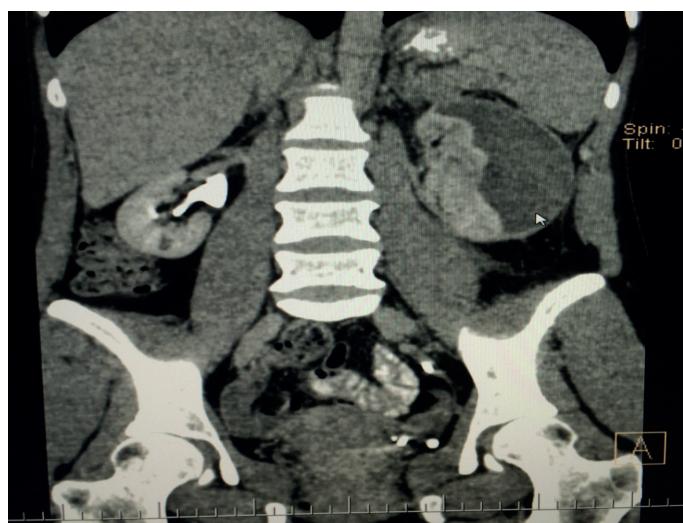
CT: left kidney hematoma, hemangioma in right kidney parenchyma.
